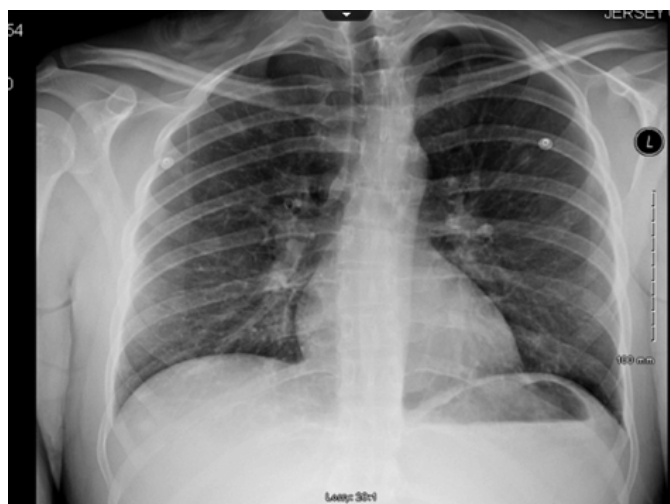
Chest X-ray upon presentation.
